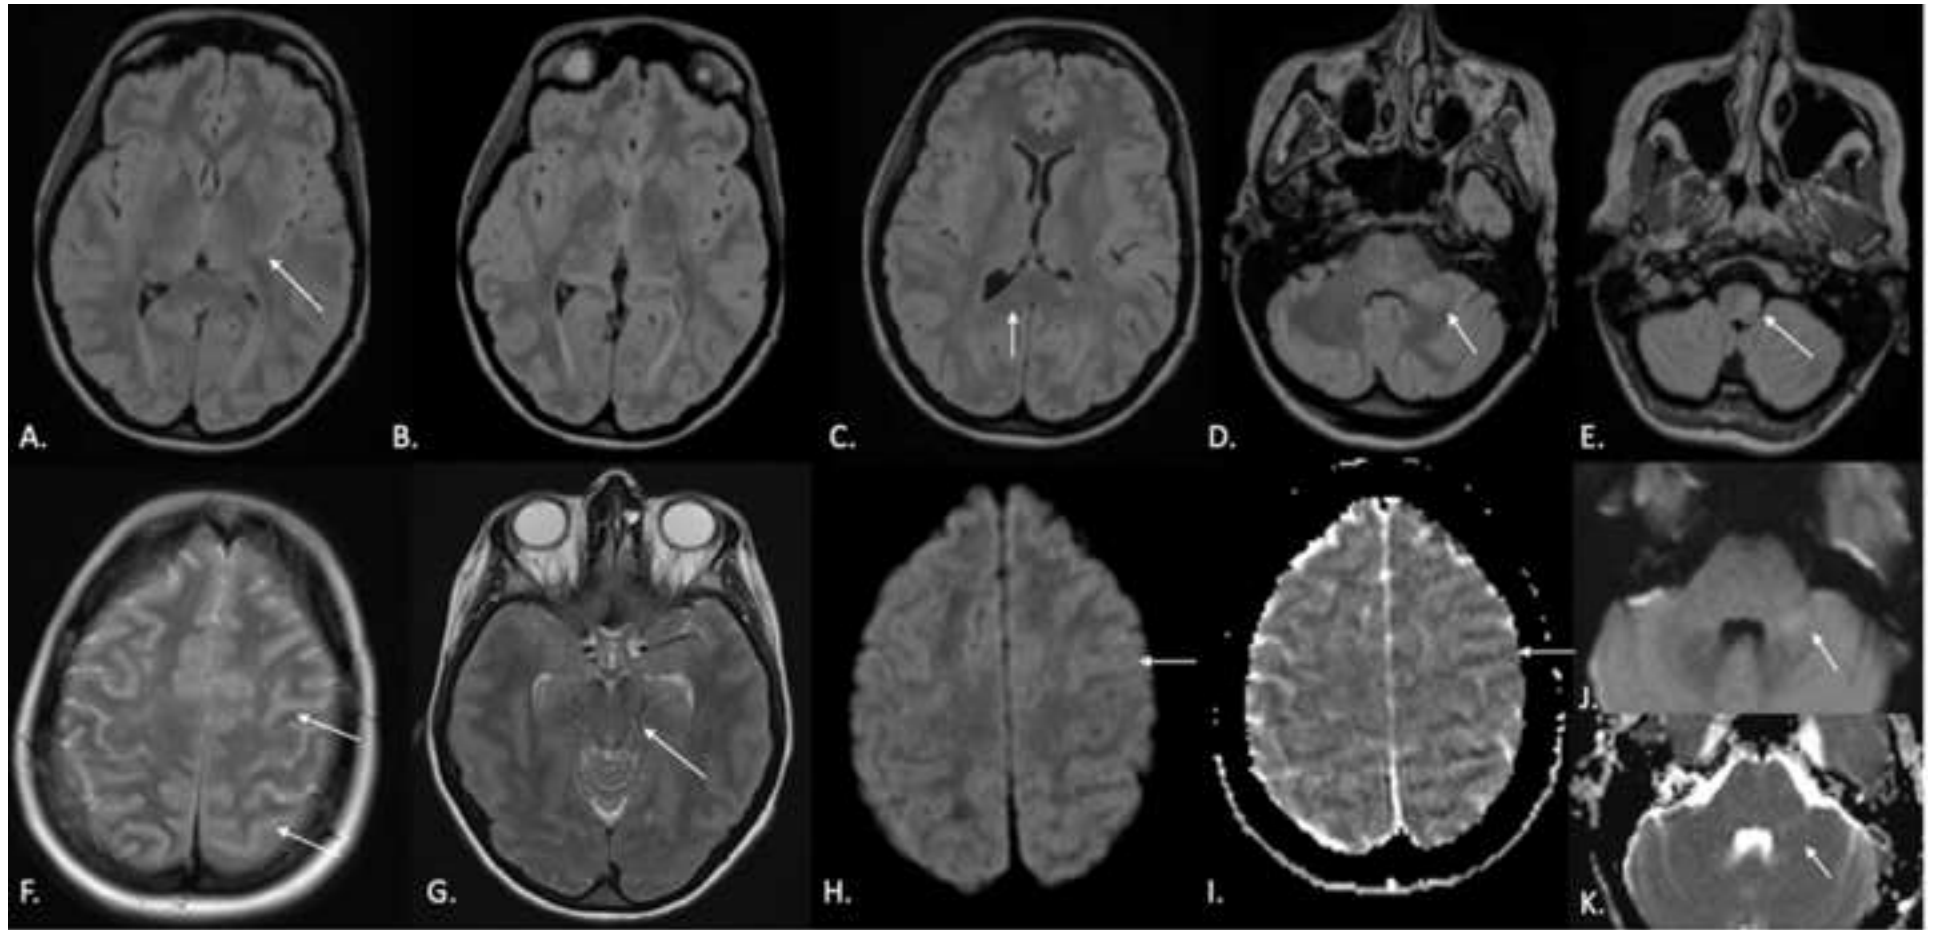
Encephalitis changes on MRI head. A-E: Axial 3D-FLAIR images demonstrating abnormal hyperintensity within the posterior limb of the left internal capsule (arrow, A), bilateral thalami (arrow, B), splenium of the corpus callosum (white arrow, C), middle cerebellar peduncle (arrow, D), and left side of the medulla (arrow, E). F-G: Axial T2-sequence highlighting extensive cortical swelling (arrows, Image F) and resulting early uncal herniation with brainstem mass effect (arrow, Image G). H-K: DWI (H and J) and ADC maps (I and K) demonstrate patchy low ADC signal suggesting reduced diffusivity within cerebral cortex (arrows, Images H and I) and the left brachium pontis lesion (arrows Image J and K).
